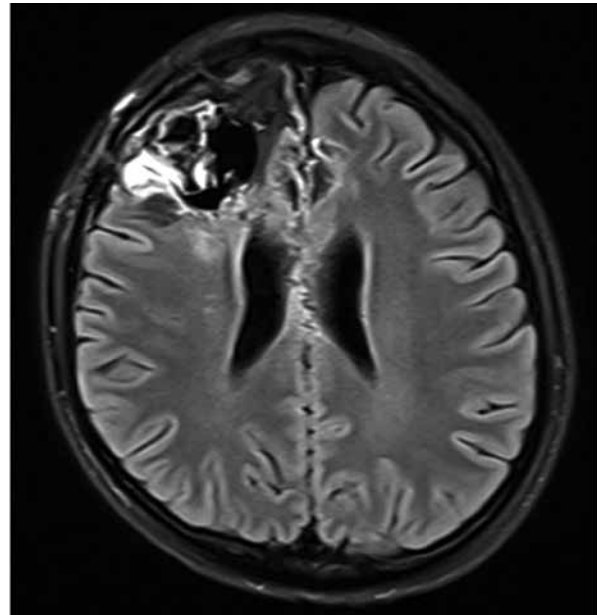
Follow-up magnetic resonance imaging, 2022 January 4th further evolution of haemorrhagic and post-ischemic changes. In the right and left frontal lobe as well as in the corpus callosum, areas of malathion, laminar necrosis and hemosiderin – slightly smaller than in the previous study
